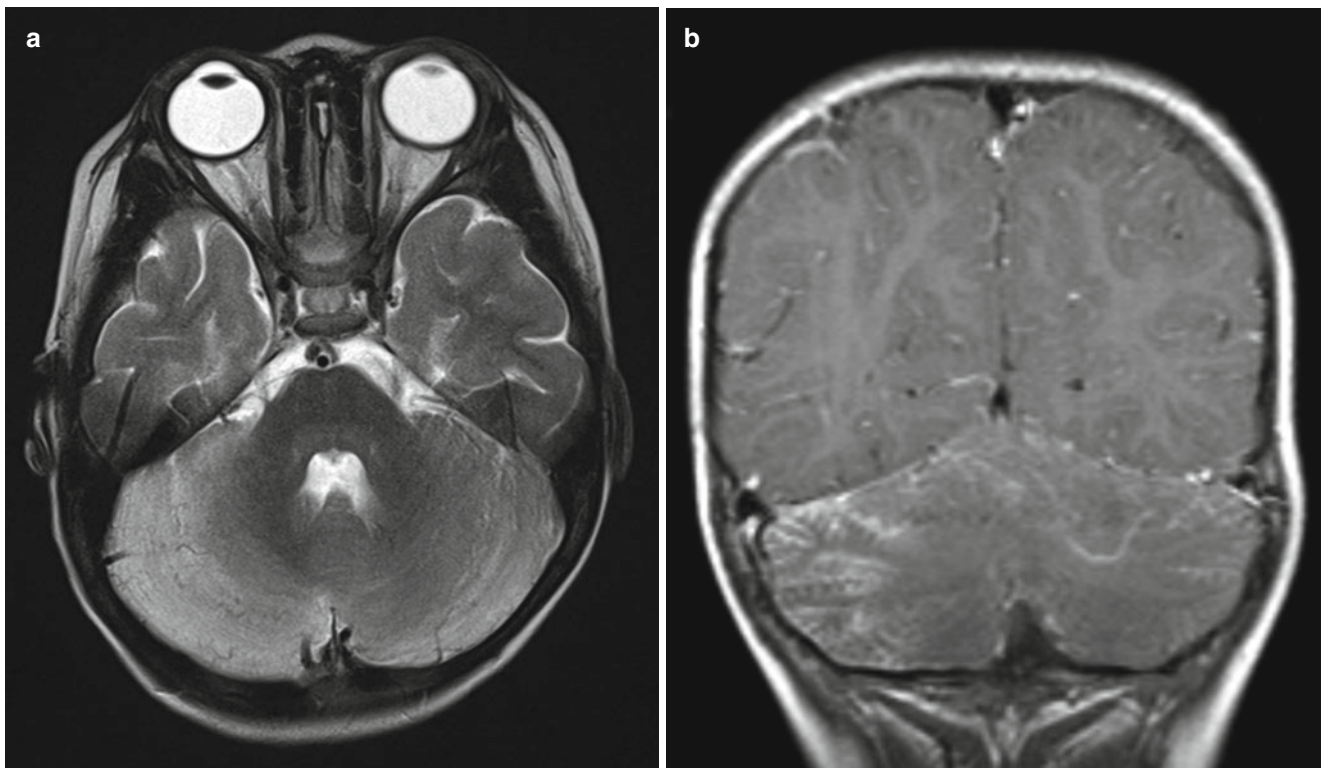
Rhombencephalitis after HFMD due to enterovirus. (a) T2-weighted image shows diffuse cerebellar high-intensity signals predominantly in the right hemisphere. (b) Postcontrast image shows diffuse cerebellar hemispheric enhancement along the folia
